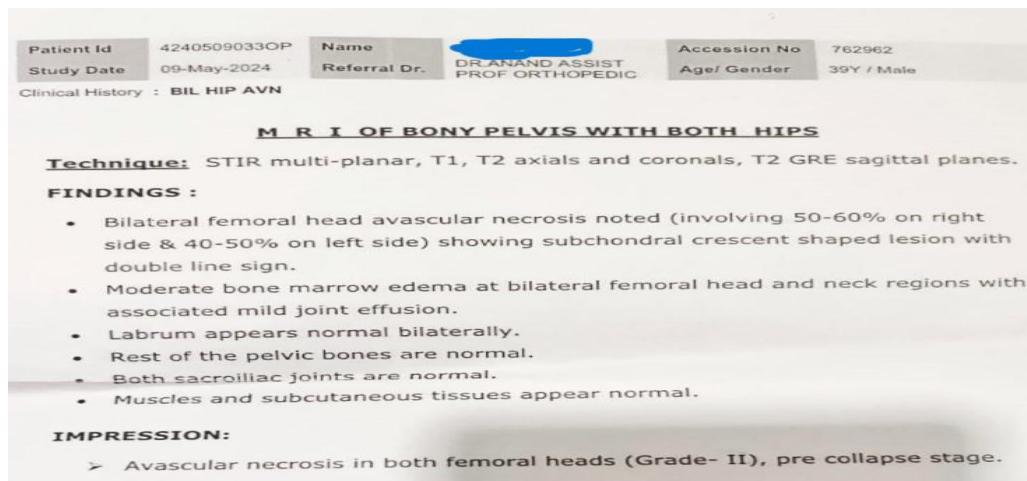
MRI Pelvis (Both Hips) dated 09-05-2024 showing features of bilateral Avascular Necrosis- Stage II (right hip) and Stage II (left hip).
